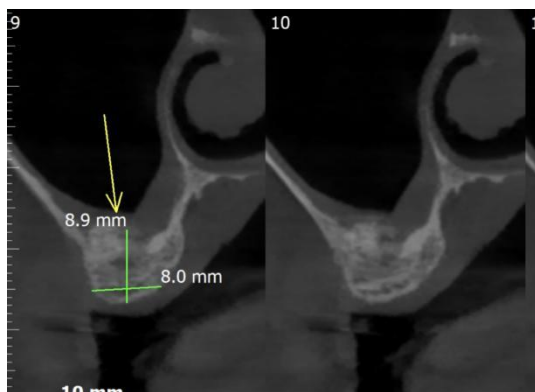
CBCT after 8 months
